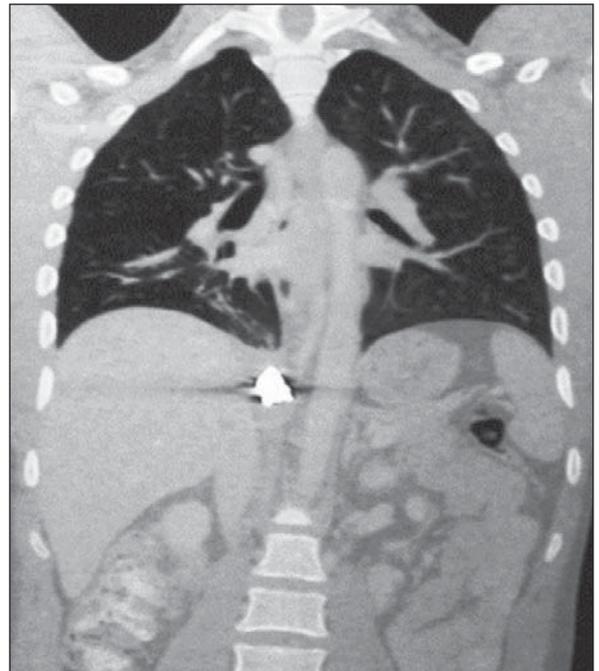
Coronal thoracoabdominal CT slice showing the fragmented bullet.
